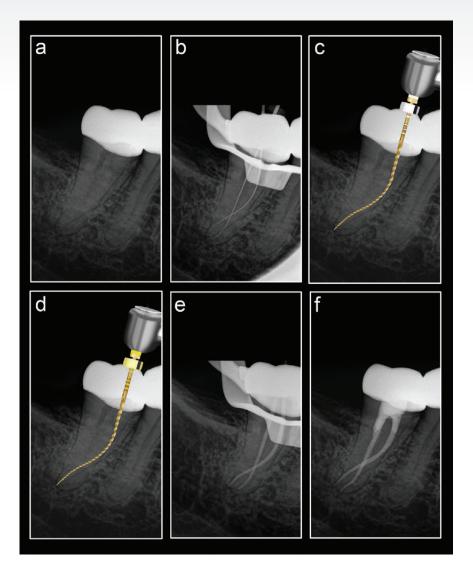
(a) Pre-operative peri-apical radiograph of non-vital mandibular right second molar; (b) Length determination peri-apical radiograph; (C) Glide path enlargement with the TruNatomy Glider; (d) Root canal preparation with the TruNatomy Small file; (e) Conefit peri-apical radiograph; (d) Postoperative peri-apical radiograph after obturation
